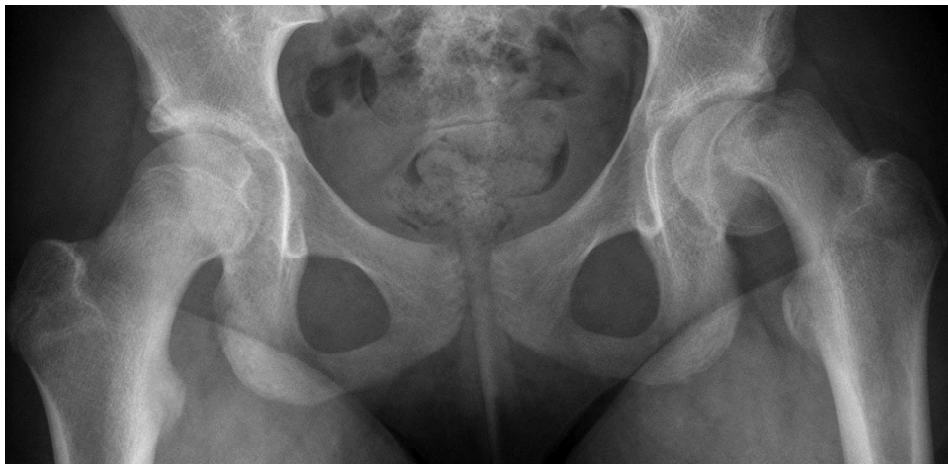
A slipped capital femoral epiphysis of the left hip is shown on the radiograph. (Case courtesy of Prof Frank Gaillard, Radiopaedia.org, rID: 8229)
